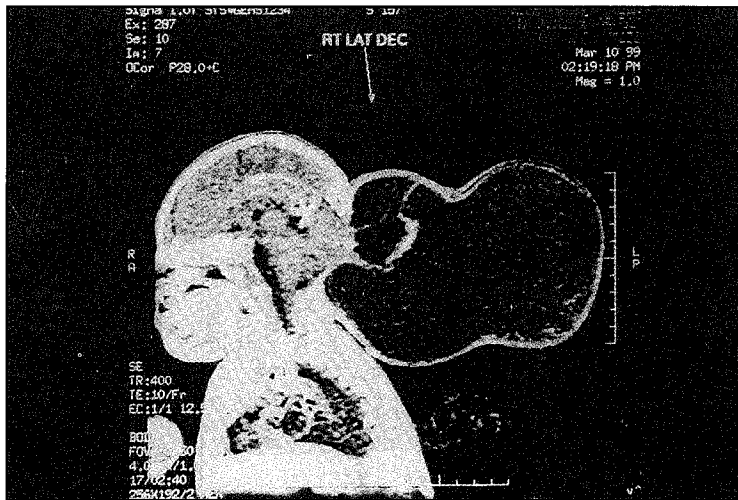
MRI TIWI showing a large occipital meningo-encephalocele. Part of the cerebellum is herniated through the skull defect. The site for sinus confluence appears to be preserved.
